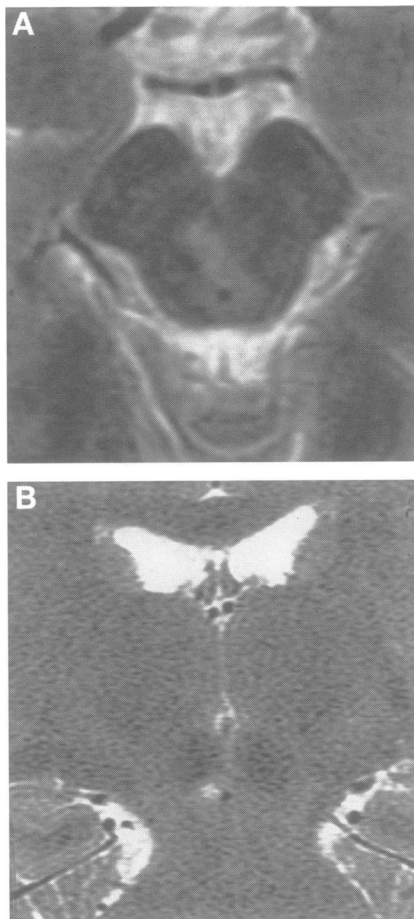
Axial (A) and coronal (B) T2 weighted MRI, 4500/102 (repetition time/echo time), through the midbrain showing increased signal intensity in the right paramedian midbrain, anterior to the periaqueductal grey and inferior to the red nucleus
